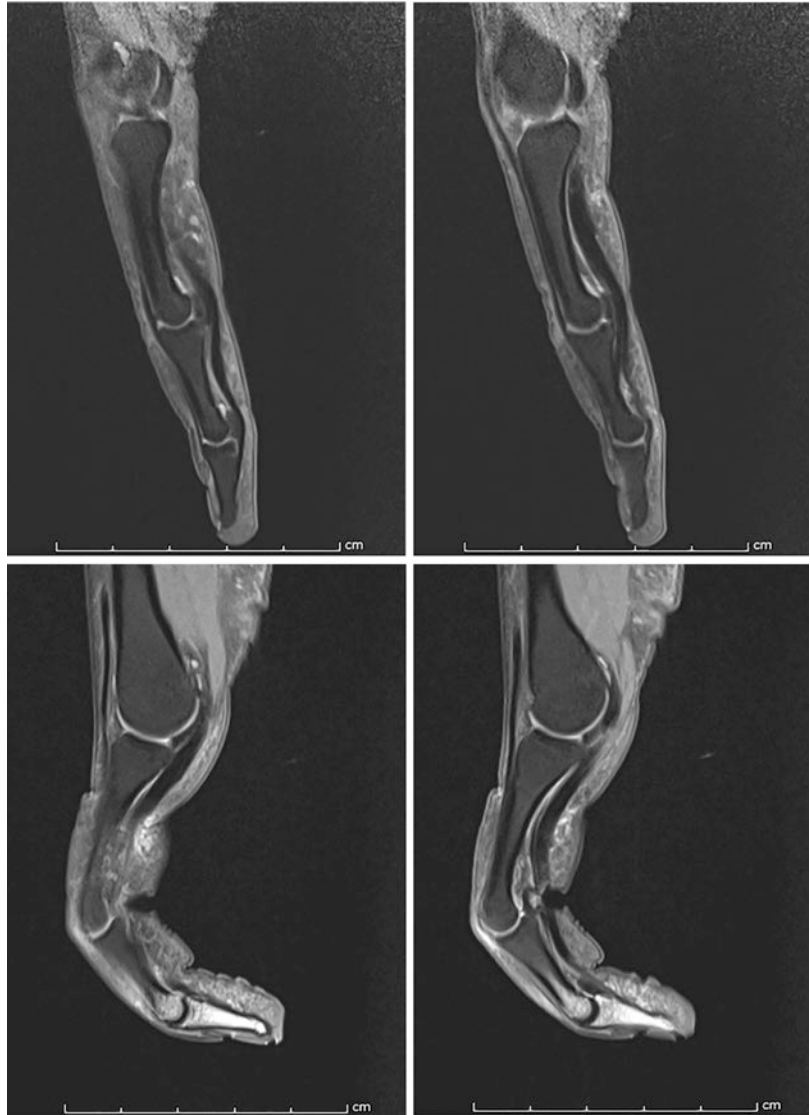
Normal flexor tendon–phalangeal distances seen on sagittal MRI sequences at rest (*top*) and on finger stress (*bottom*)
